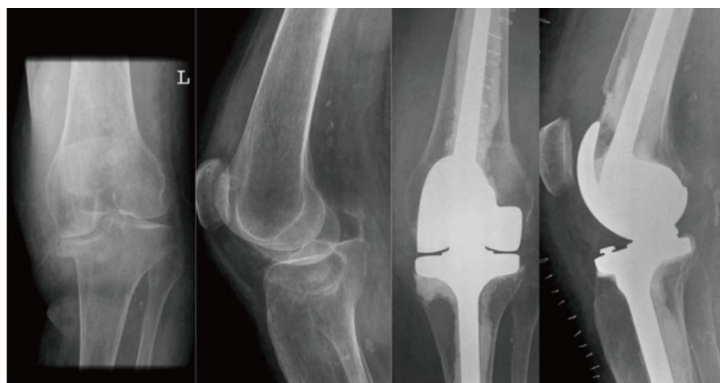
Primary total knee arthroplasty following tibial plateau fracture. Proximal tibial fracture with poor bone stock and post-operative radiograph showing rotating hinge prosthesis.
